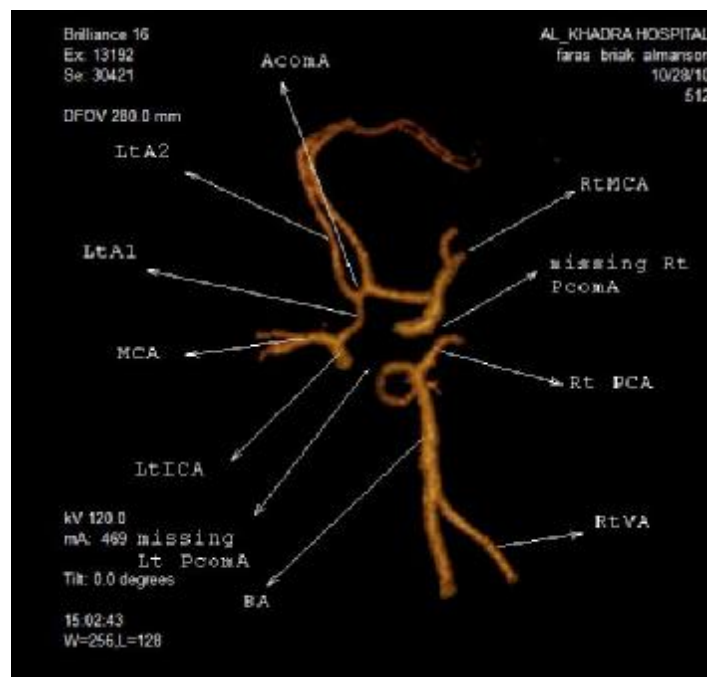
CTA showing bilateral missing PcomA with classical anterior circle.
